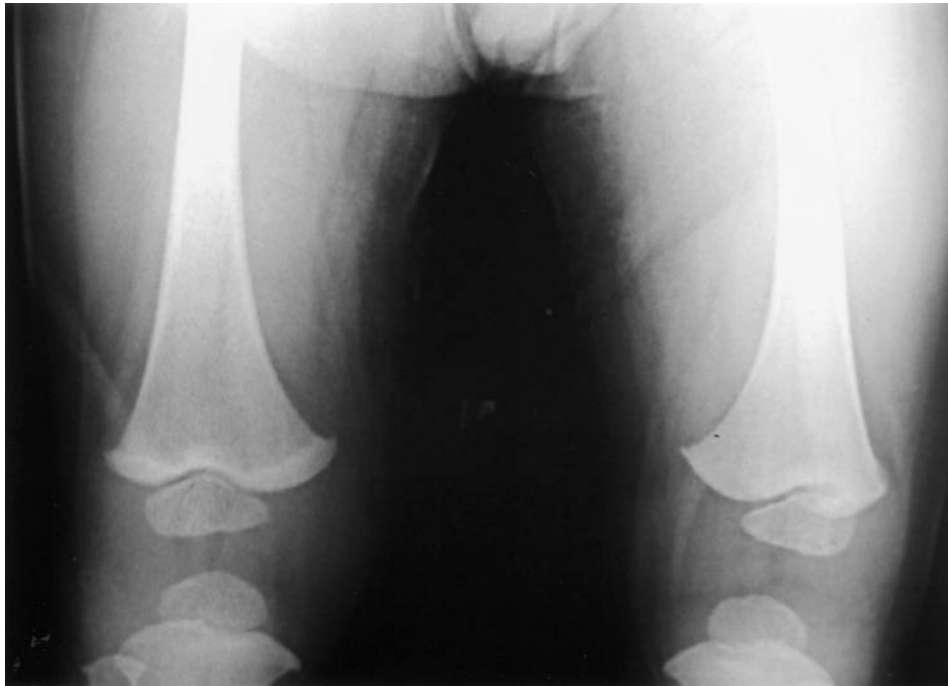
Long-bone radiograph demonstrating possible lead line at distal right femur of patient 5.
